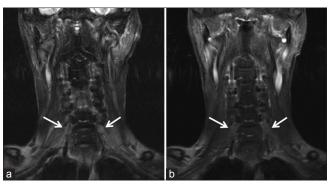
Coronal T2-weighted (a) and contrast-enhanced T1-weighted (b) magnetic resonance images show thickening and moderate contrast enhancement in bilateral C7 spinal nerve roots (arrows)
